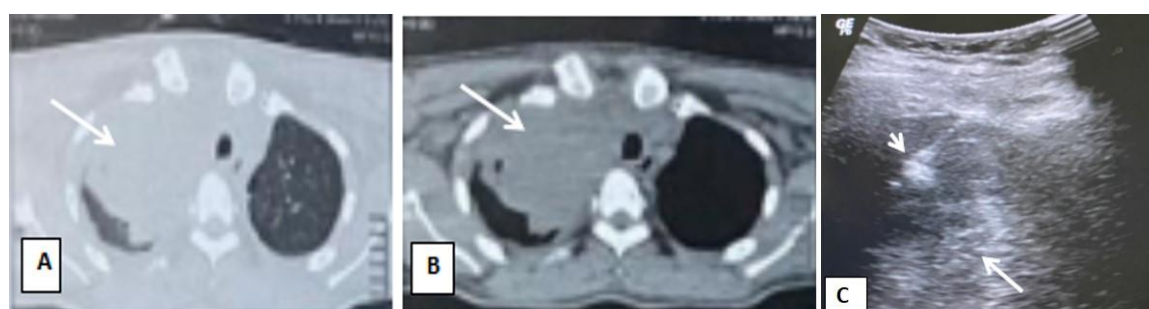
(A) CT lung window. (B) Mediastinal window shows right upper lobe apical segment mass lesion (arrow). (C) TUS low frequency convex probe B-mode image shows heterogeneous lesion (arrow). Tru-cut needle (arrowhead) is seen within the lesion.
